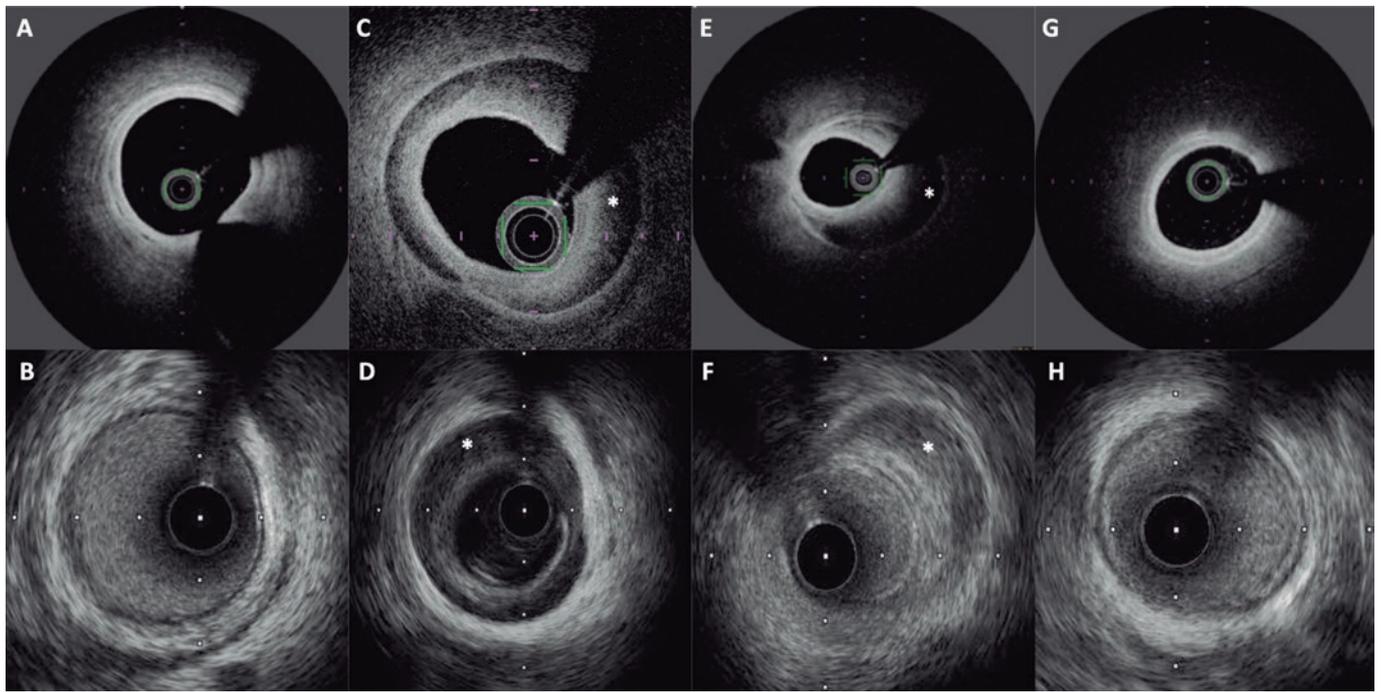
Optical coherence tomography (upper row) and intravascular ultrasound (lower row) showing the healthy proximal (A, B) and distal (G, H) segments of the left anterior descending coronary artery, and a spontaneous coronary artery dissection with intramural hematoma (asterisk) in the mid-segment (C-F).
